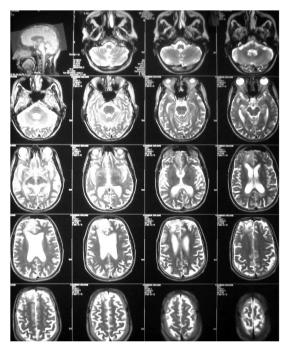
MR images after radiation therapy showing gliosis in right frontal area
